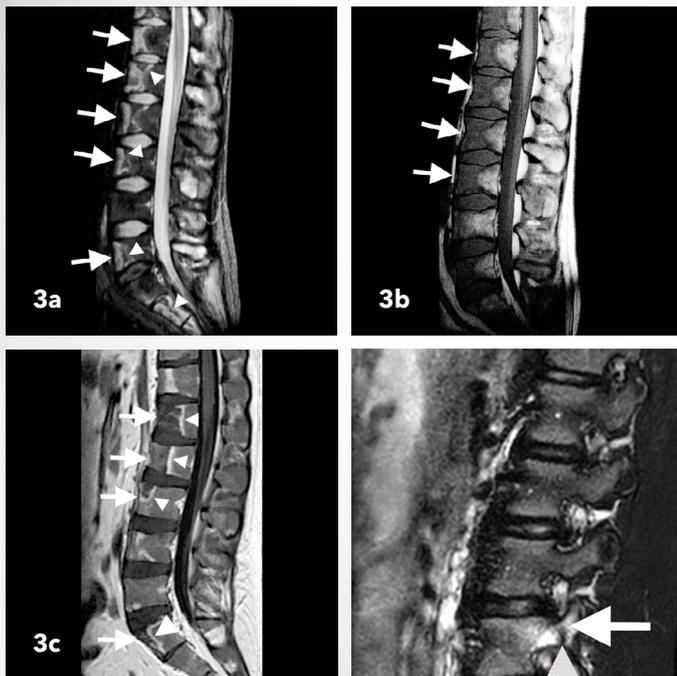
a. Sagittal T2-w MRI scan of the lumbar spine and sacrum showing multiple areas of high signal in the anterior portions of T11 to L4 vertebral bodies, L5 and the sacrum (arrows). Note that there is some suggestion of a double line sign in some of the bone infarcts (arrowheads). b. Sagittal T1-w MRI scan of the same area shows low signal in the infarcted areas (arrows) due to replacement of fatty marrow by oedema. c. The contrast-enhanced T1-w scan shows rim enhancement (arrowheads) of the infarcts corresponding with the areas of neovascularity.
